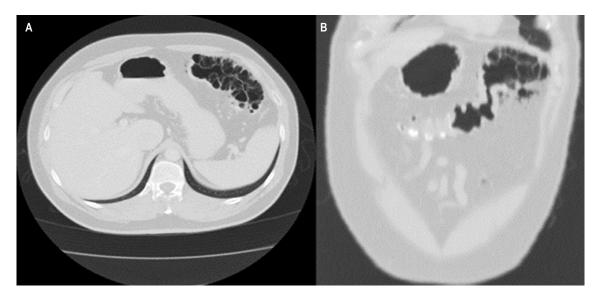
CT scan showing cystic intestinal pneumatosis in the splenic flexure of the colon, associated with multiple pneumoperitonea. A. Axial view. B. Coronal plane.
